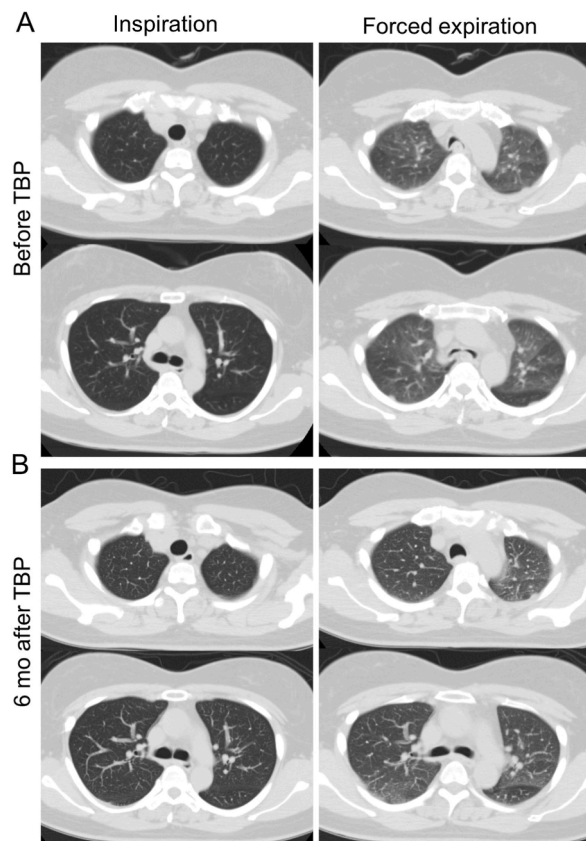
Comparison of CT images at end-inspiratory and forced expiratory phases before tracheobronchoplasty (TBP) (A) and 6 months after TBP (B) at the level of the aortic arch and at the level caudal to the carina. Protrusion of the posterior membranous portion of the central airway and resulting airway collapse is evident at expiration before TBP. However, these findings are significantly improved after TBP.
